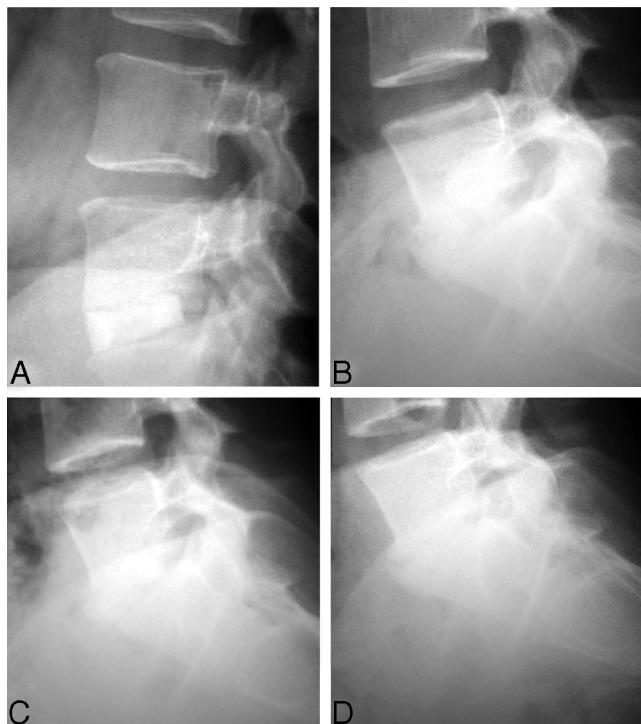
Sequential radiographs of pseudarthrosis development after ALIF with FRA and rhBMP-2 at various stages after surgery: immediate postoperative (A), 3 months (B), 6 months (C), and 9 months (D).
